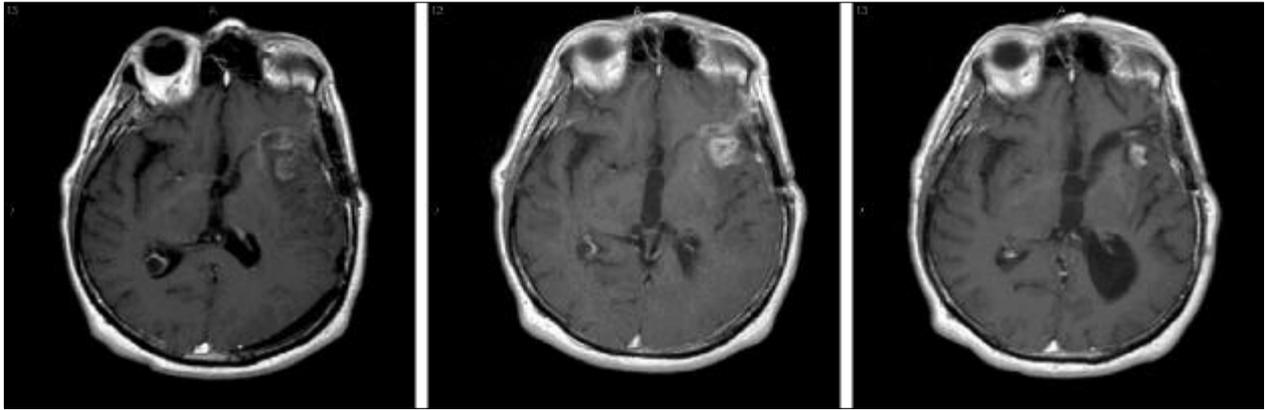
Regression of recurrent glioblastoma following vaccination with autologous glioma cells admixed with IL-4 transfected fibroblasts. Axial gadolinium-enhanced T1-weighted MR images obtained from the most recently treated patient. The 3-month post-vaccine image (right) shows a remarkable resolution of enhancement in comparison to the pretreatment study (left), which was obtained after surgical debulking but before vaccination, or 1-month post-vaccine (middle). Enhanced lesions were measured independently by a neuro-radiologist.
